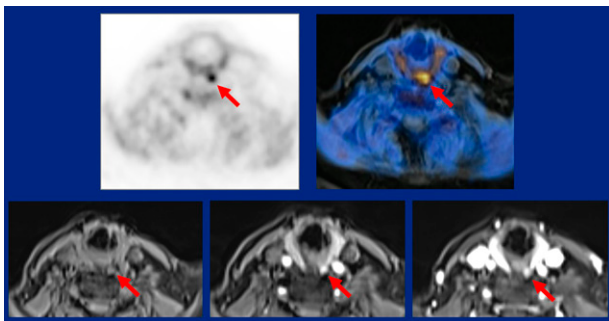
PET/MR imaging of parathyroid adenoma (arrows) with early arterial enhancement. Top left: PET; top right: MRI. Bottom: Dynamic contrast-enhanced MRI sequence (left to right): native phase, early arterial phase, and arteriovenous phase.
